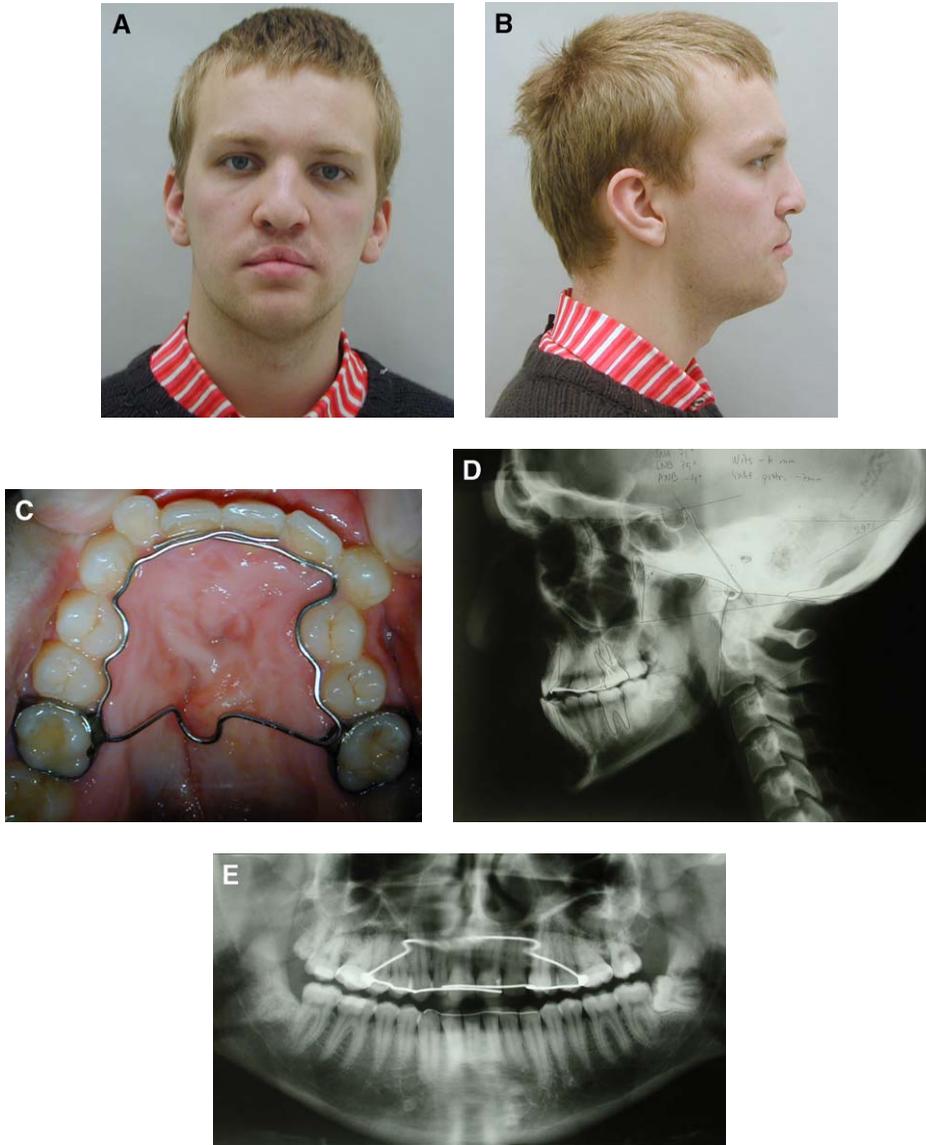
Frontal (A) and lateral (B) view of 18-year-old man with bilateral cleft lip and palate and maxillary hypoplasia. (C) Extensive palatal scarring put the patient at risk for developing velopharyngeal insufficiency with traditional LeFort I maxillary advancement. Panoramic radiograph (D) and lateral cephalogram (E) of patient.
